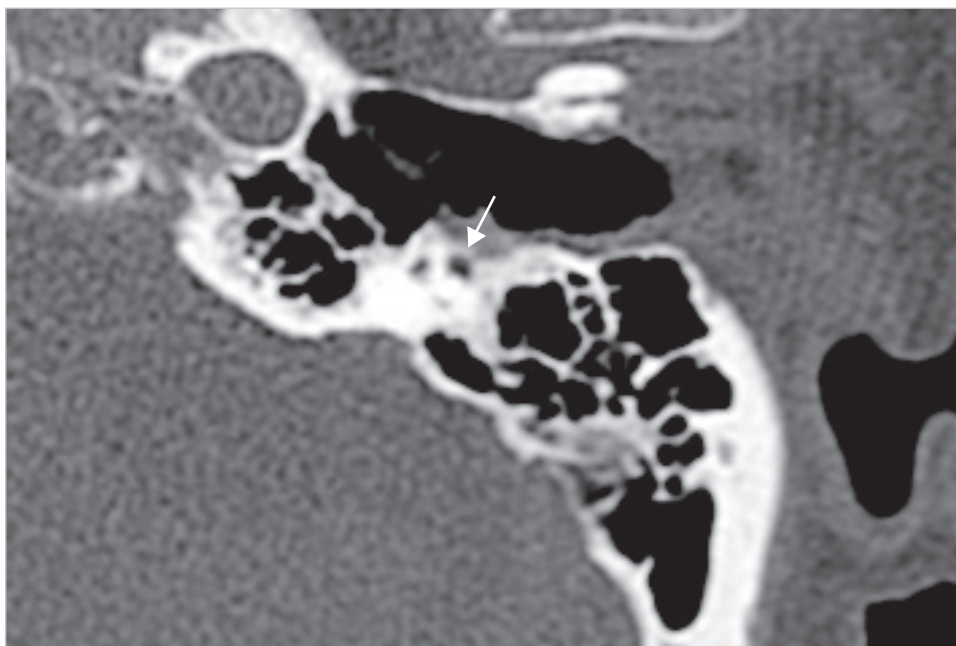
The preoperative axial CT shows bone erosion in the posterior wall to reaching the area of the facial nerve (*arrow*).
